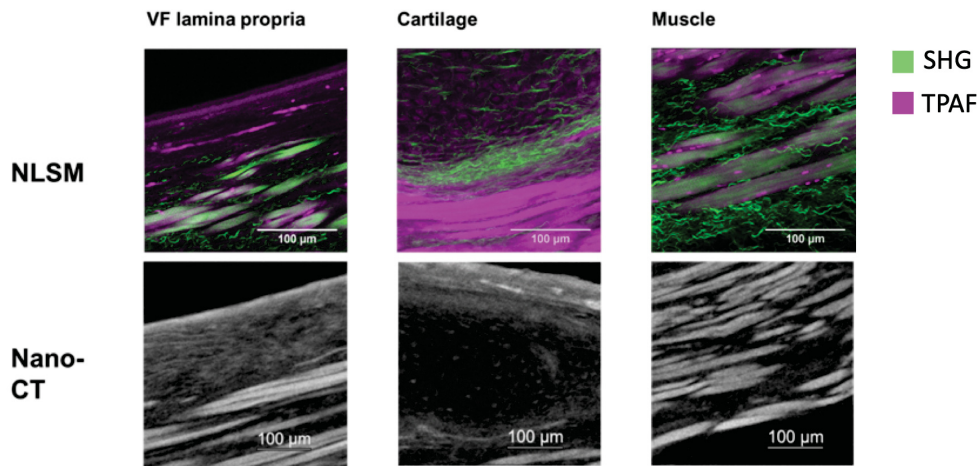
Representative images of laryngeal tissue structures visualized with NM and CT. In the NM images, resolution down to 248 nm is attained in (x,y). In the CT images, resolution down to 800 nm is attained in (x,y,z).
